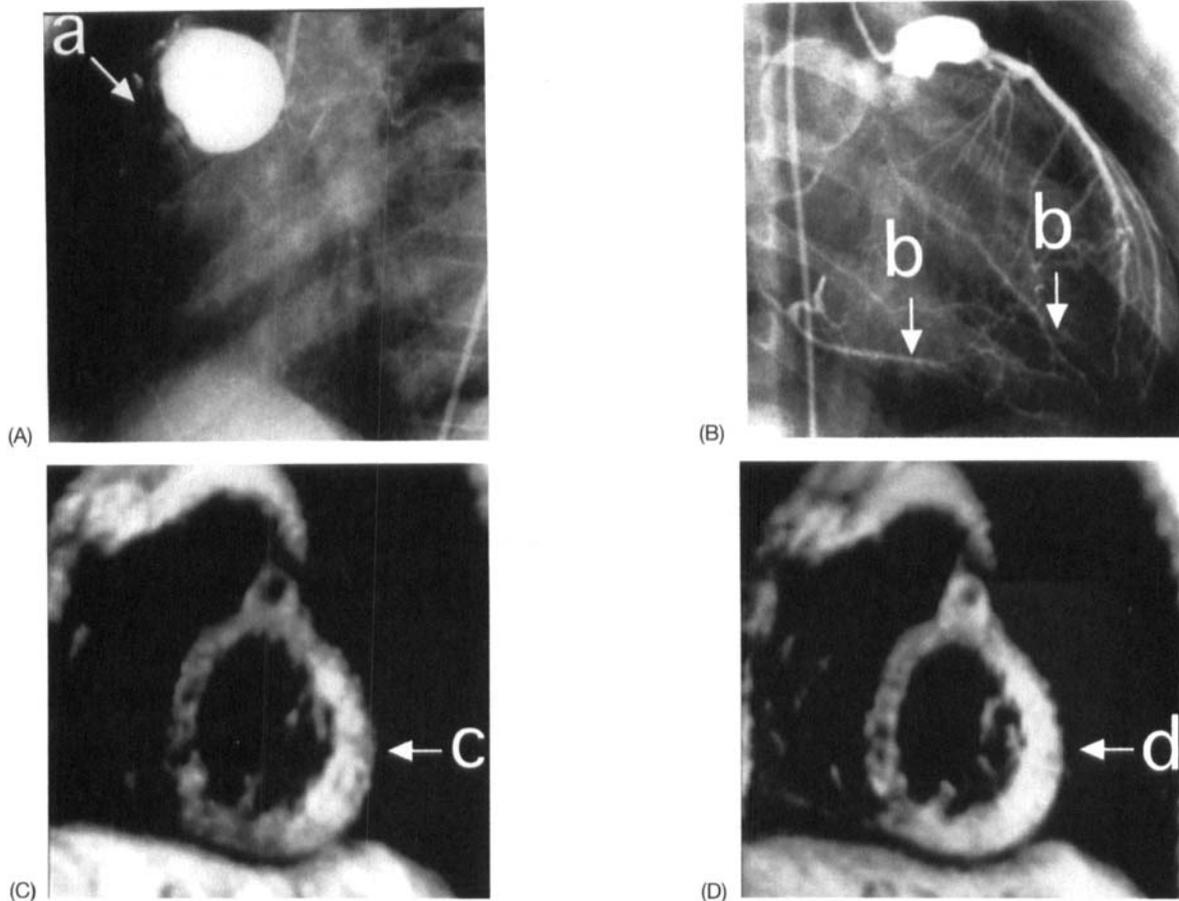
Case No. 2 (7.6-year-old boy): Coronary angiography (A and B) and magnetic resonance imaging (C and D) at 10 months after the second acute myocardial infarction. Complete occlusion is observed in the right coronary artery (RCA) (arrow a). The left circumflex artery (LCx) is also occluded (B). Development of collateral circulations from the left anterior descending artery to the LCx and RCA are seen (arrow b). Thinning of the myocardial wall is not evident, an irregular shape of the wall is seen from the inferior wall to the posterior wall of the left ventricle (arrow c). After injection of gadolinium diethylenetriamine pentaacetic acid, heterogeneous enhancement is seen in the same region (arrow d).
